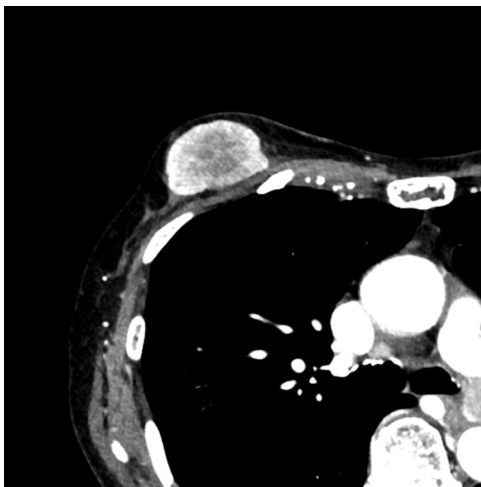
An axial enhanced CT image of the right breast showed a right oval circumscribed homogeneously enhanced breast mass.
